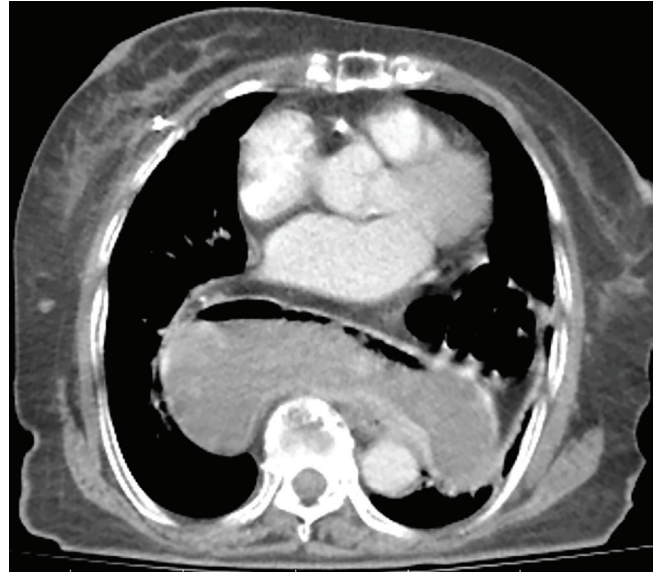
Appearance of giant hiatal hernia on CT, coronal section.
